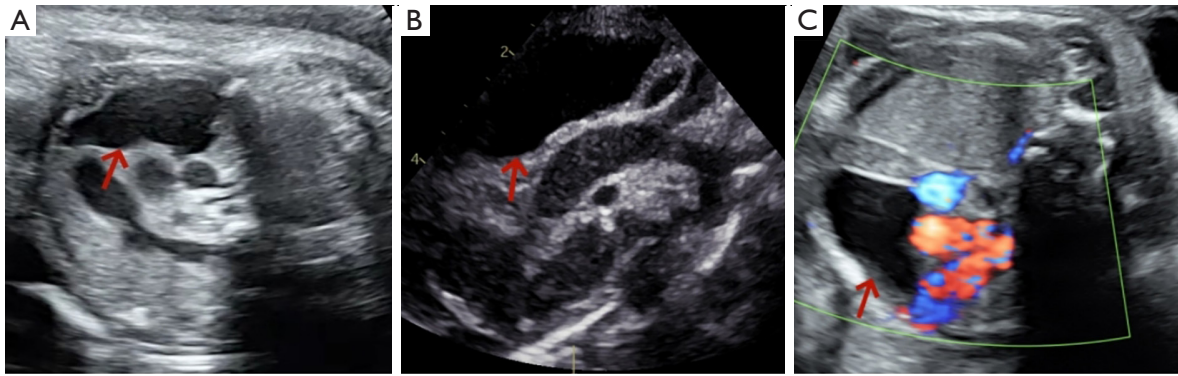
Ultrasound examination. Ultrasound examination (A,B) revealed a hypoechoic, avascular, single-compartment cystic mass (red arrows) in the right posterior chest of the fetus. Color Doppler ultrasound (C) showed no blood flow signal. The cystic mass is showed by red arrow.
